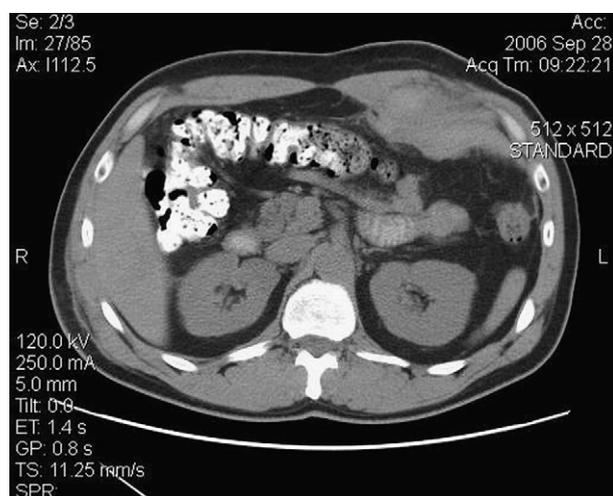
Computed tomography scan of the abdomen demonstrating a left-sided type II RSH in a 38-years old man after laparoscopic cholecystectomy.
